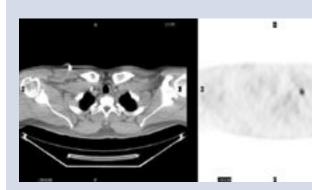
Axial scans form CT and PET scans of a patient with nonsmall cell lung cancer (NSLC).
